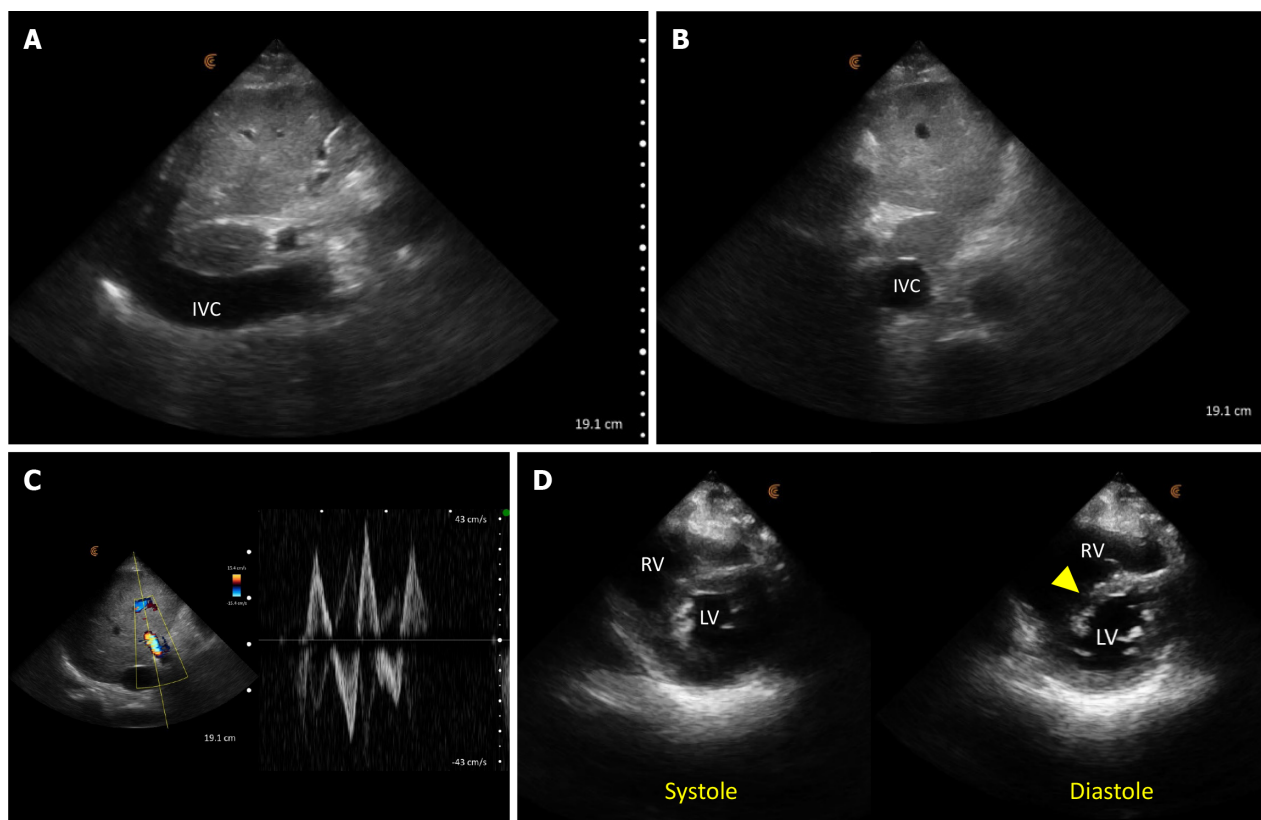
Point-of-care ultrasound images demonstrating findings suggestive of volume/pressure overload. A: A dilated inferior vena cava (IVC) in long axis; B: IVC transverse view shows a circular vessel as opposed to normal elliptical shape; C: Pulsatile portal vein Doppler with a to-and-fro pattern (normally it's continuous); D: Parasternal short axis cardiac view showing interventricular septal flattening (arrowhead) predominantly in diastole. RV: Right ventricle; LV: Left ventricle.
